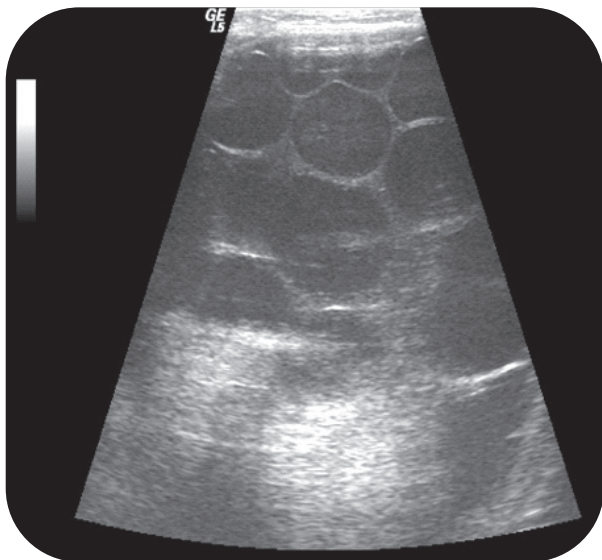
Ultrasonography shows multi-septated cystic mass in left thigh giving “cart wheel appearance”. These findings are typical for hydatid cyst
